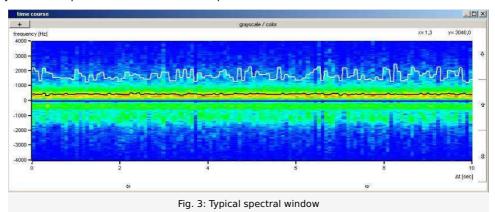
Typical Doppler signal
